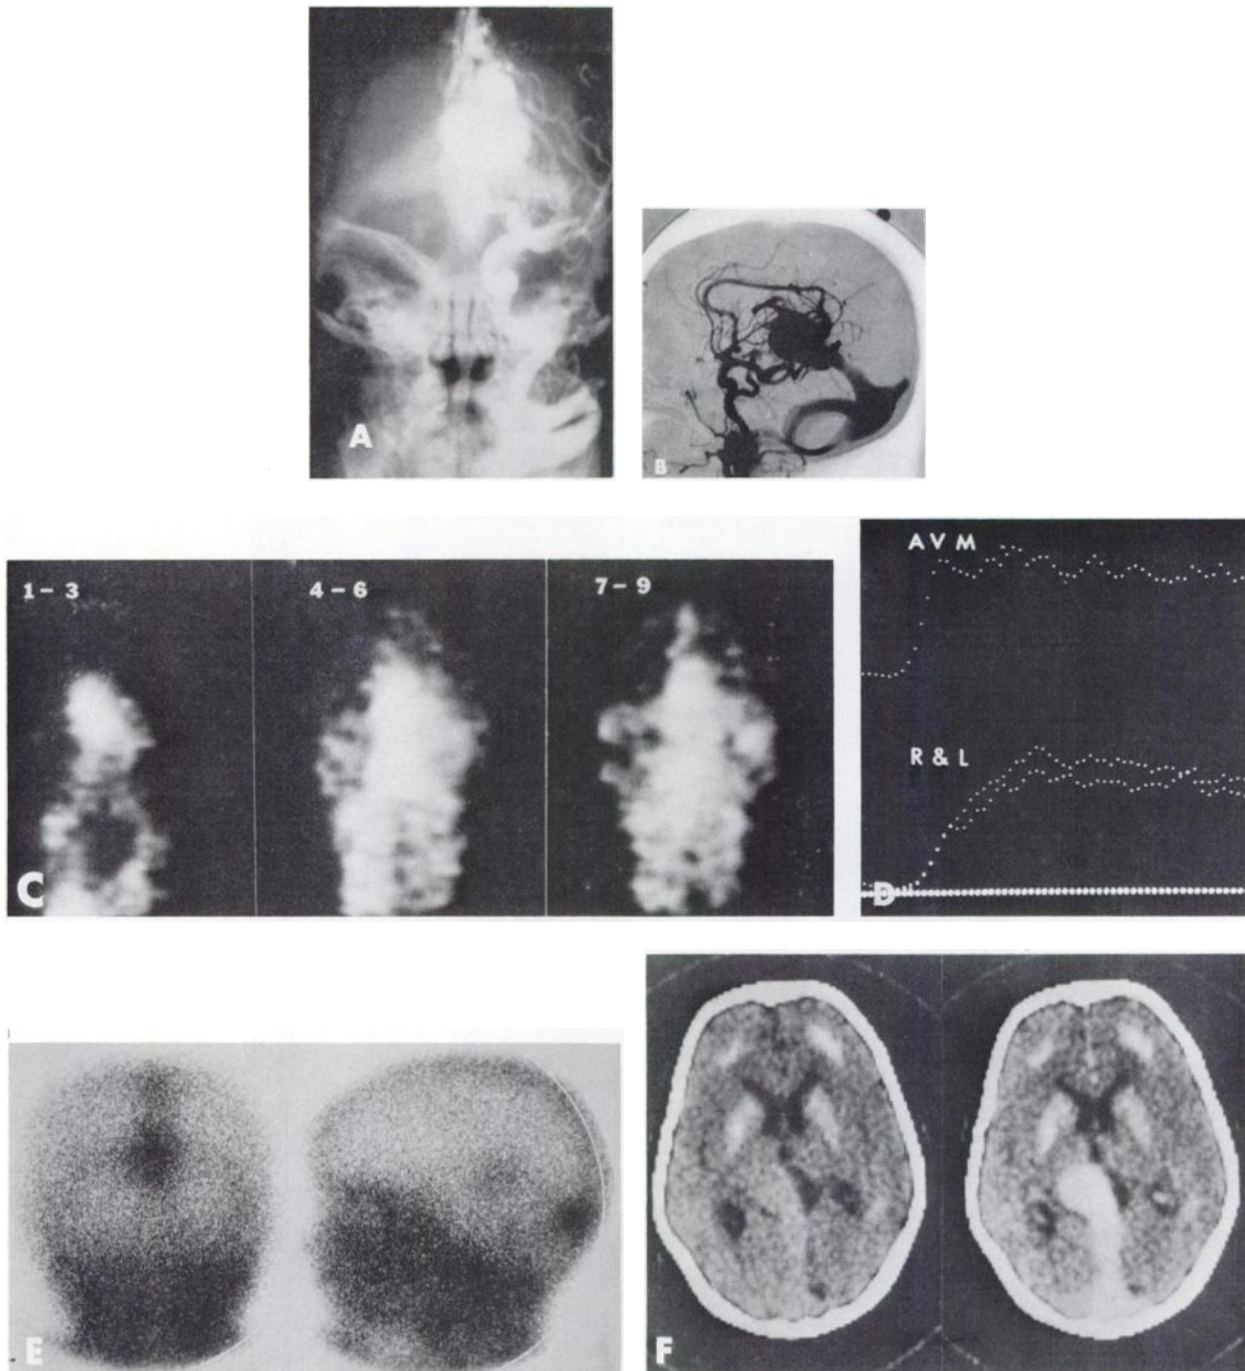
Three-year-old girl (Patient 4) with great cerebral vein of Galen malformation. AP cerebral angiogram (A) with subtraction lateral (B) show prompt flow into great cerebral vein of Galen from carotid system (including a persisting trigeminal artery). Venous drainage was into straight sinus and torcular Herophili; superior sagittal sinus was not in main drainage route. Anterior dynamic study (C) shows vascular midline malformation, diminished appearance of tracer in cerebral hemispheres, and delayed imaging of superior sagittal sinus until the 7- to 9-sec interval. Curves (D) show nearly equal hemispheric perfusion (R & L) while the AVM is more promptly perfused (base line shifted upward for display purposes). Delayed static scintigrams (E, posterior and left lateral) show the malformation. CT scans before and after contrast injection (F) show cerebral calcifications and distortion of left side of quadrigeminal cistern by a mass whose vascular nature was demonstrated by iothalamate.
